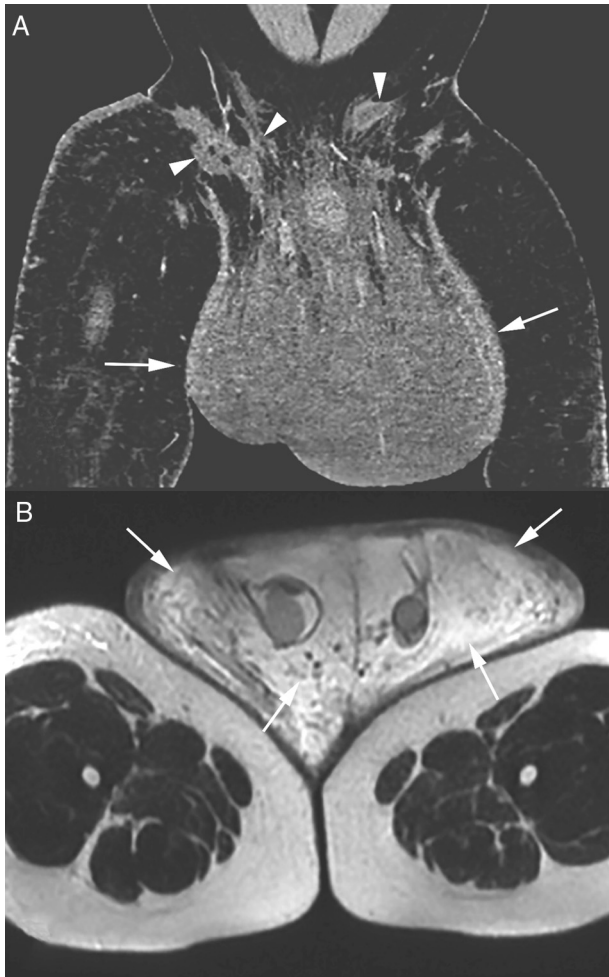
Post-contrast coronal computed tomography of the pelvis (A) showing isodense scrotal enlargement (arrows) with multiple fistulous tracts (arrowheads) in the right inguinal region. T2-weighted magnetic resonance image of the pelvis (B) showing hyperintense scrotal enlargement due to significant subcutaneous edema (arrows).
